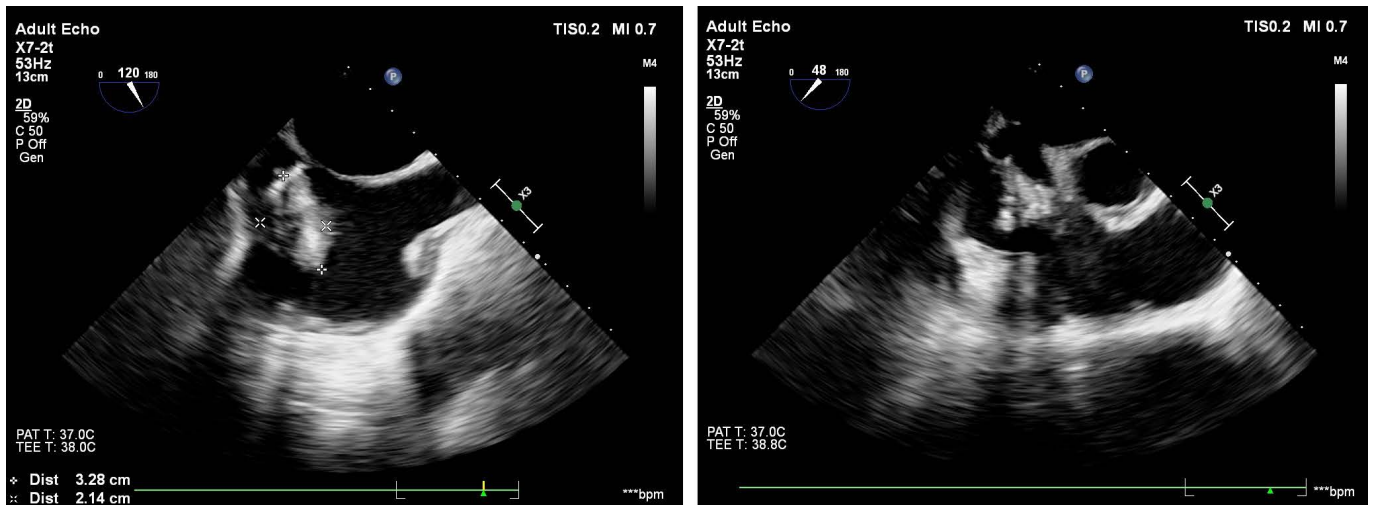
Image of transesophageal echocardiography showing a mass of 32/21 mm in the right atrium, most likely attached to the interatrial septum at the level of the inferior vena cava
